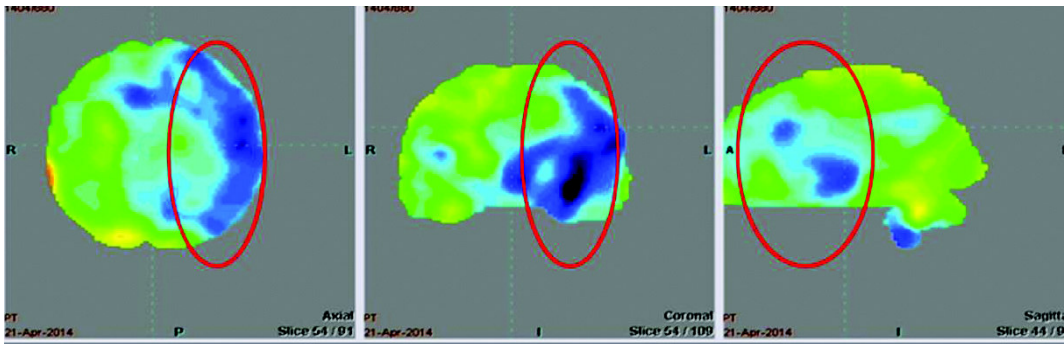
PET-CT scan 6 months after Autologous BMMNCs transplantation shows reduced blue areas signifying improved metabolism of the penumbral regions
